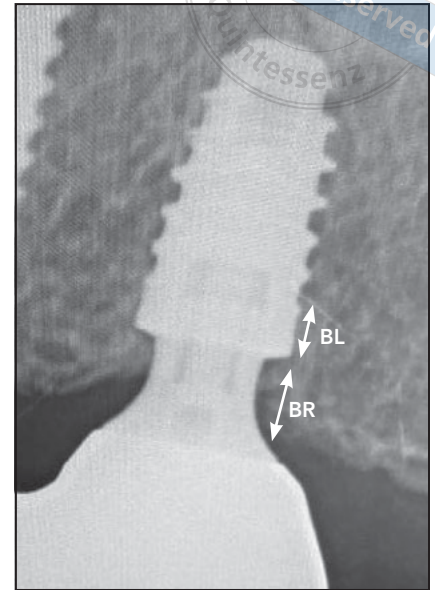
A radiographic view highlights the bone remodeling area (BR; coronal to the implant-abutment junction) and bone loss area (BL; apical to the implant-abutment junction).
